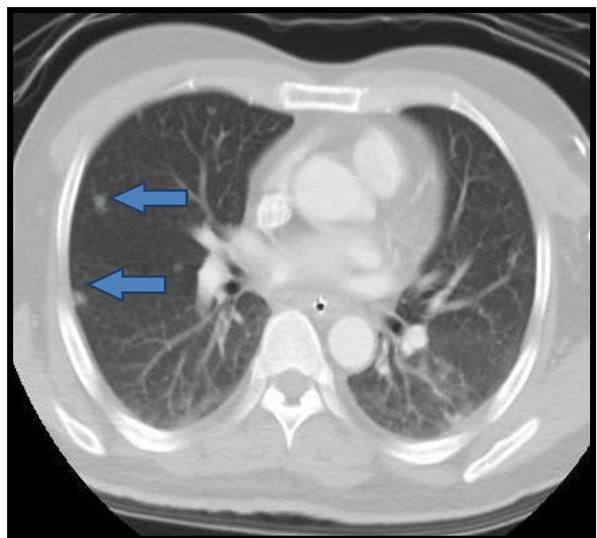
CONTRAST ENHANCED AXIAL CT THORAX showing peripheral pulmonary nodule suggestive of septic emboli
